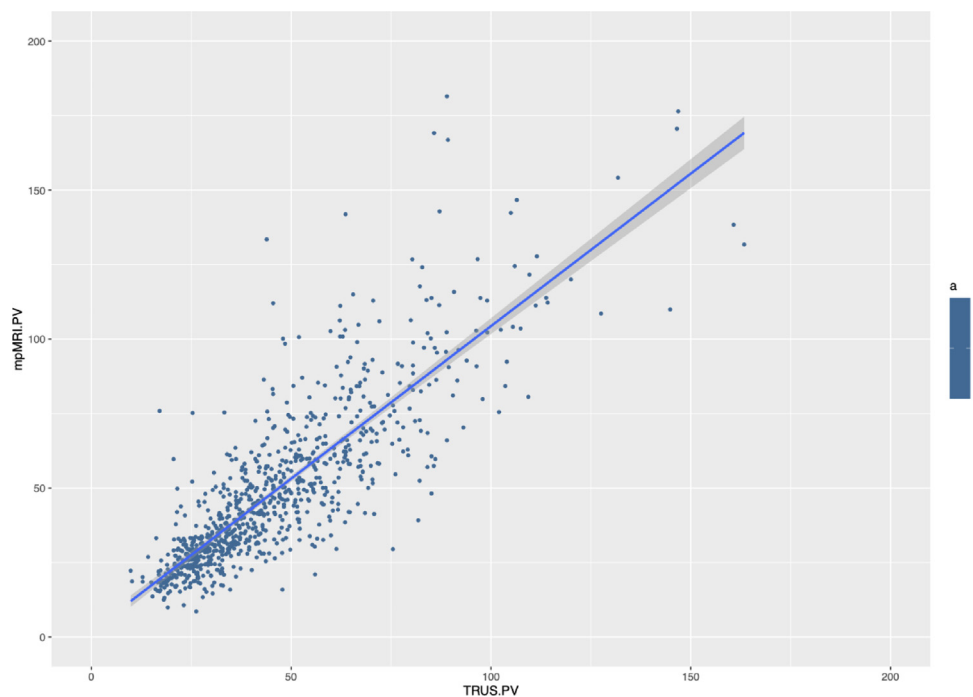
Prostate volumes measured by TRUS versus prostate volumes measured by mpMRI. mpMRI = multiparametric magnetic resonance imaging; PV = prostate volume; TRUS = transrectal ultrasound.
